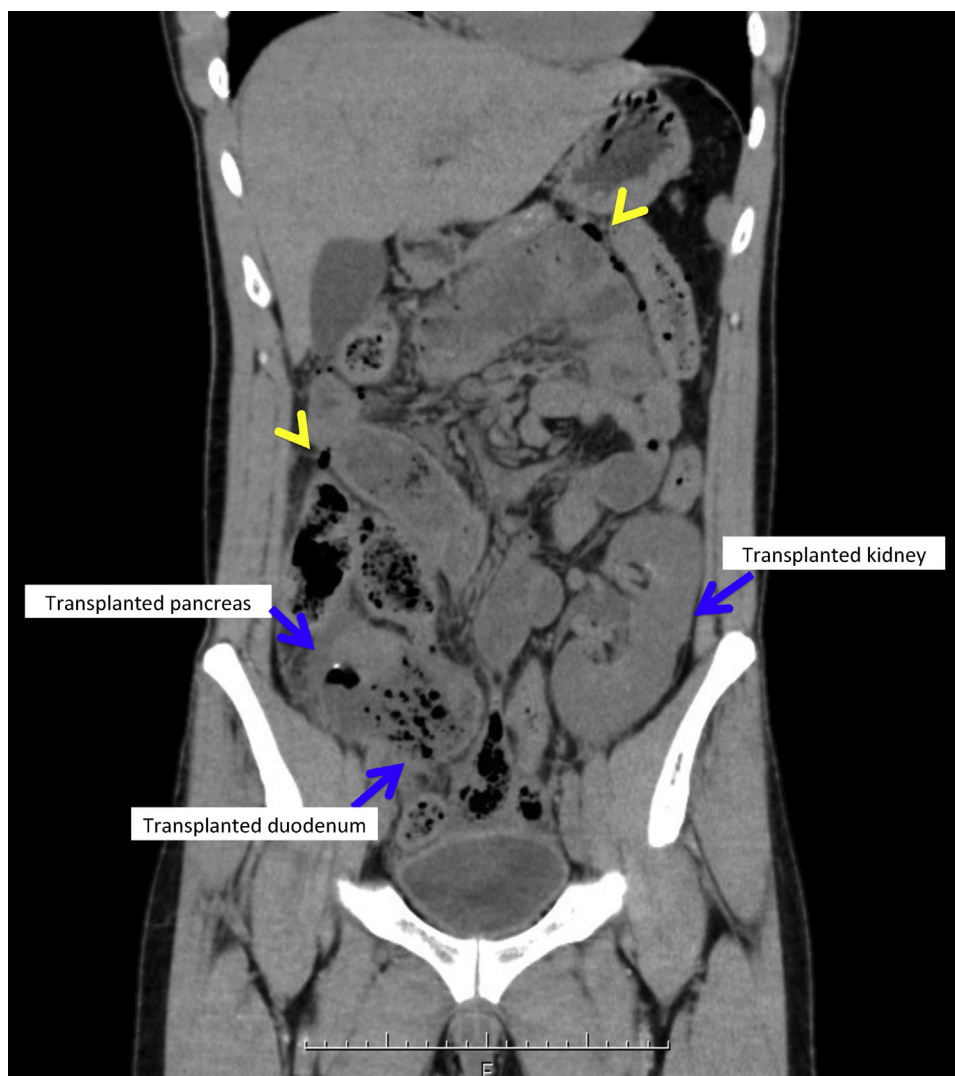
Computed tomography scan of the abdomen shows free air (arrow head) and the graft duodenum impacted with food.
